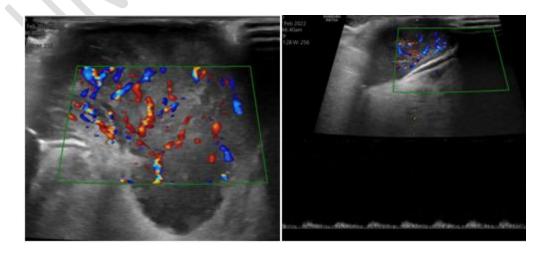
Color Doppler ultrasonographic image of tongue depicting the heterogeneously hypoechoic intramuscular lesion involving diffusely, with marked increased vascularity and showing arterial biphasic flow.
